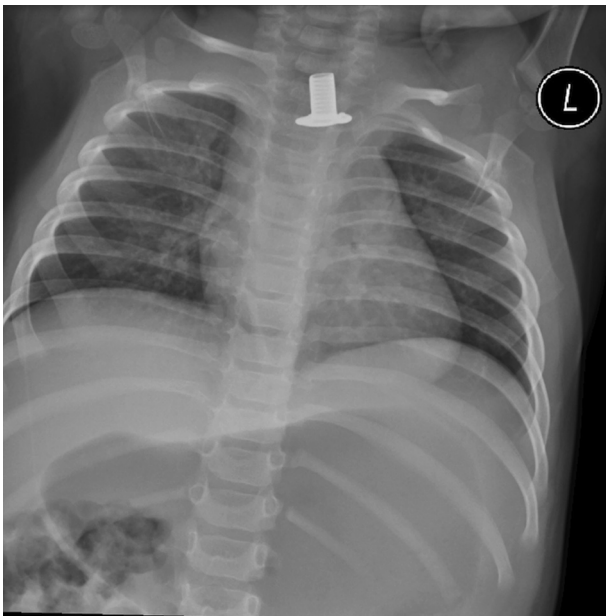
Supine chest radiograph showed a radio-opaque cylindrical foreign body with a flared lower section in the upper chest region.
